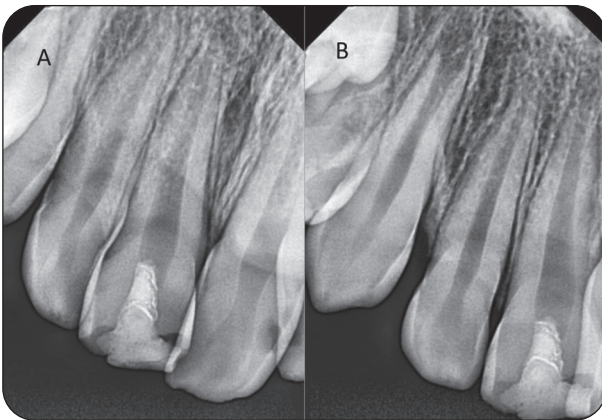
Photos of periapical x-rays taken three (a) and six (b) months postoperative show thickening of root canal walls
